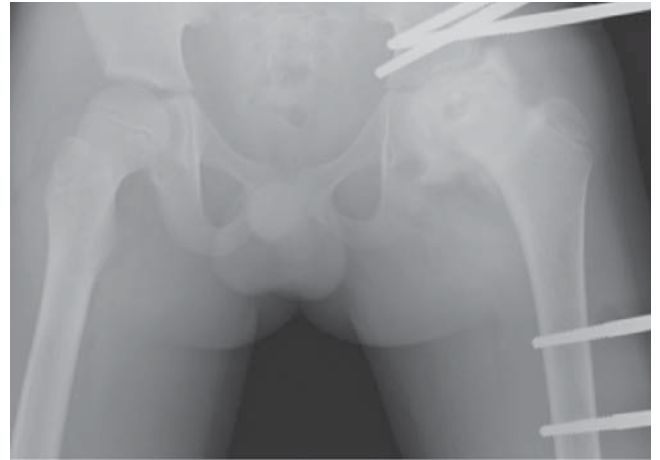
Immediate postoperative radiograph following a hip arthrogram, adductor tenotomy, and placement of a monolateral hinged external fixator for arthrodiastasis across the hip joint. Note the mild abduction positioning of the left lower extremity
